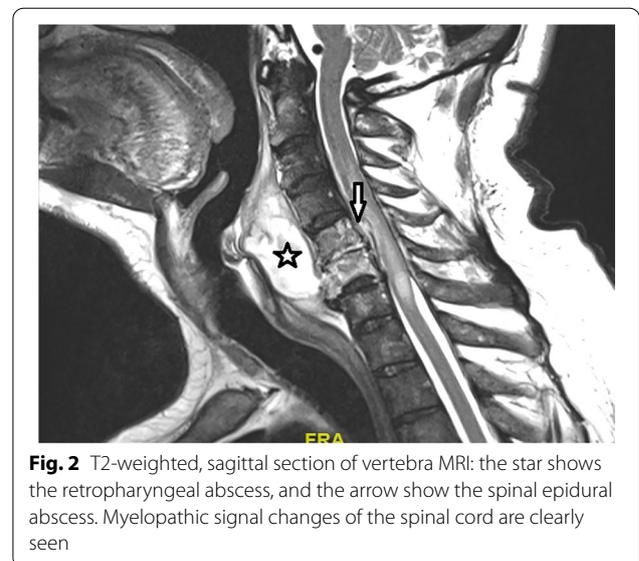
T2-weighted, sagittal section of vertebra MRI: the star shows the retropharyngeal abscess, and the arrow show the spinal epidural abscess. Myelopathic signal changes of the spinal cord are clearly seen
